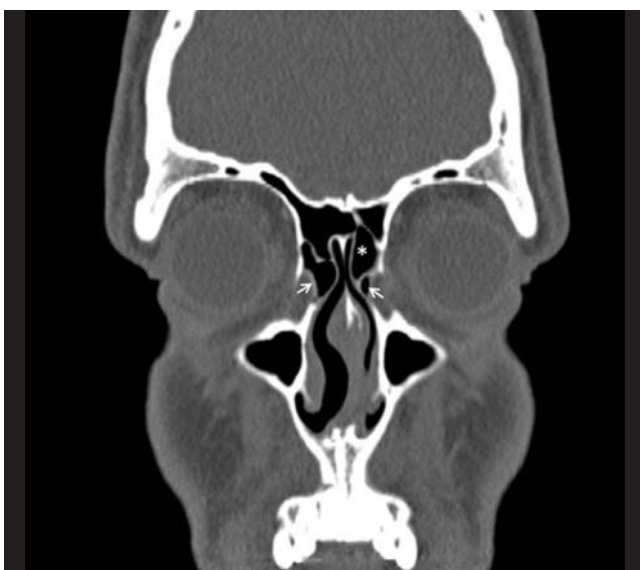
Coronal non-contrast paranasal sinus CT image shows bilateral agger nasi cells (white arrows) and frontal cell Type 1 on the left side (*).
